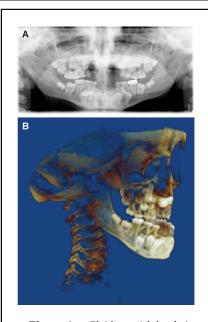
Cleidocranial dysplasia (CCD). A: Panoramic radiograph and (B) cone beam CT images of a 14-year-old boy with CCD showing the multiple retained primary teeth and multiple impacted permanent teeth and supernumerary teeth.
